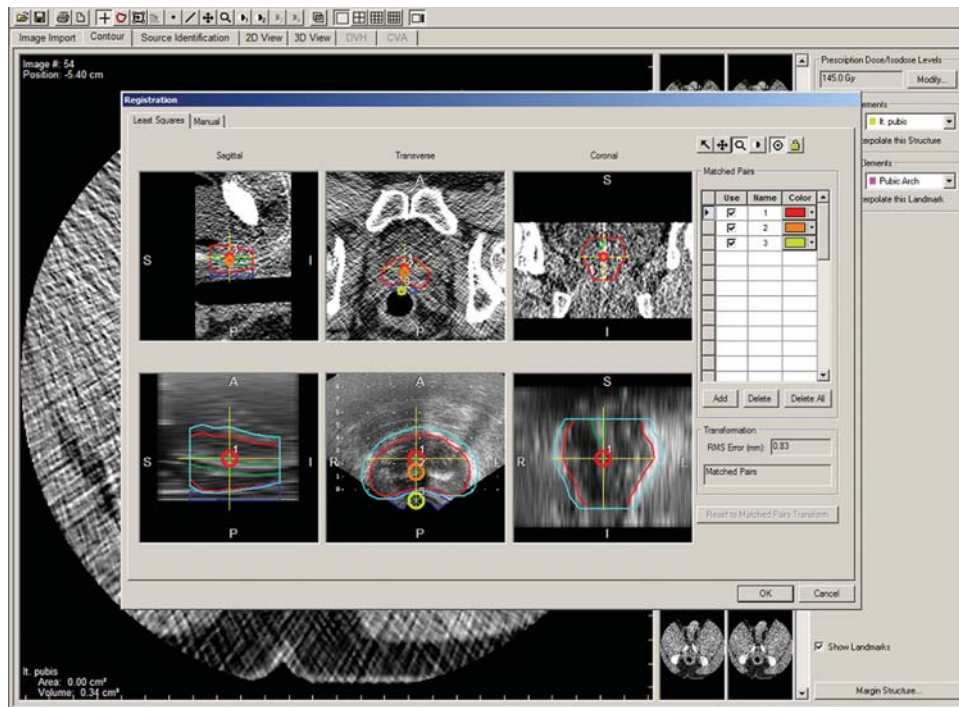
An example of fusion registration using a radiation treatment planning system. The urethral anterior wall (red), urethral posterior wall and anterior rectal wall (yellow) were selected as the points for fusion registration. We could validate the anatomical landmarks (urethra, rectal anterior wall and prostate) on both TRUS and CT. Contour: urethra (green), rectal anterior wall (blue), prostate outline (red) and planning target volume of the prostate (cyan).
